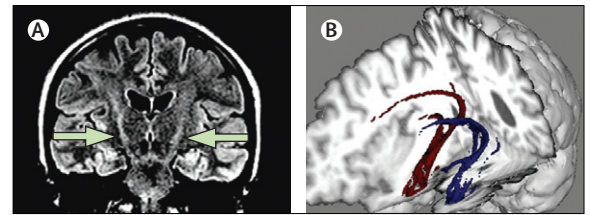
Standard and experimental MRI sequences in patients with ALS
